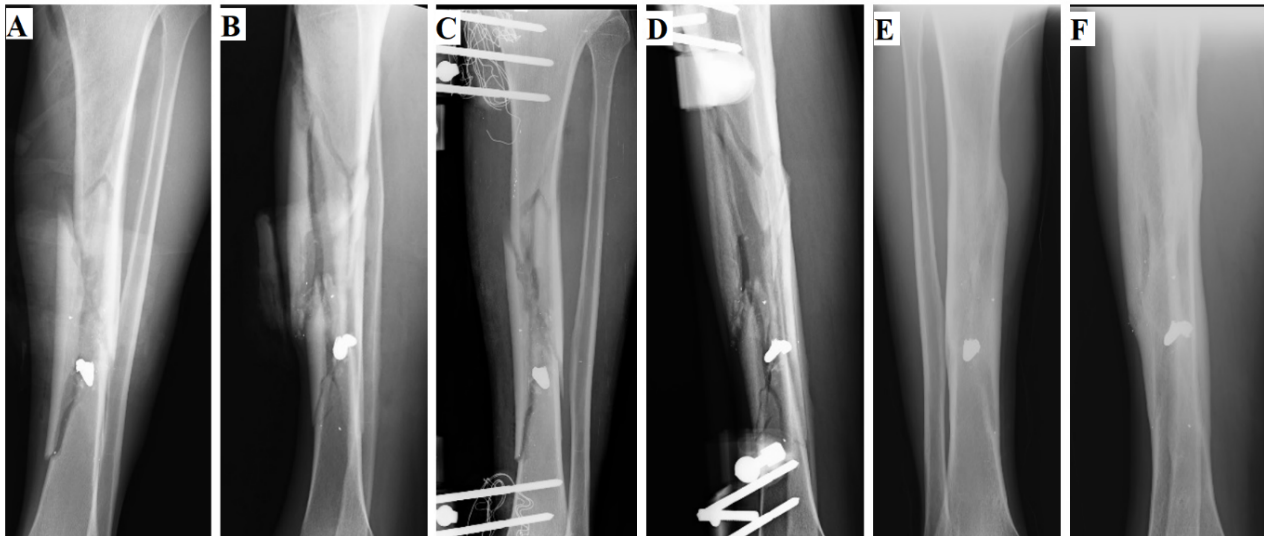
External fixation in tibia diaphysis fracture (A: The first anterior-posterior radiography image, B: The first lateral radiography image C: Anterior-posterior radiography image after surgery, D: Lateral radiography image after surgery , E: Anterior-posterior radiography image after union, F: Lateral radiography image after union)
